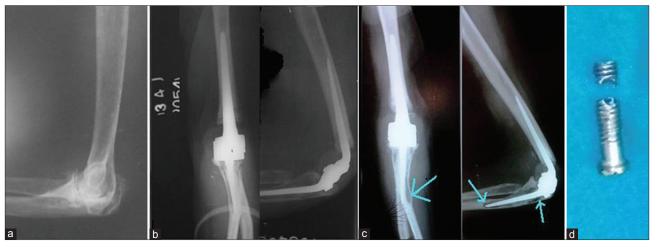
(a) Preoperative X-ray of left elbow joint (lateral view) in a post burn patient showing bony ankylosis of elbow in 90° joint (b) Postoperative X-ray of left elbow joint (anteroposterior and lateral views) showing Baksi implant *in situ* (c) X-ray left elbow (anteroposterior and lateral views) 117 months of followup showing radiolucency around stem (sky blue arrow) (d) photograph showing broken hinge screw at the level of threaded hole which lead to implant failure
